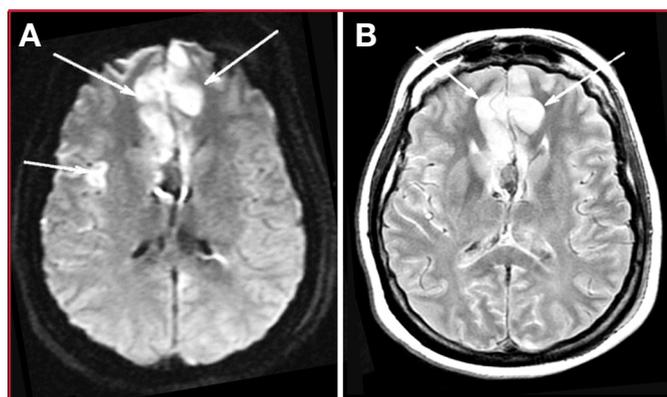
Diffusion-weighted (A) and fluid-attenuated inversion recovery (B) computed tomographic (CT) images demonstrating hemorrhage-related ischemic injury in both anterior and right middle cerebral artery territories (arrows) at admission in a 44-year-old woman with Hunt and Hess Grade V SAH from a left anterior cerebral artery aneurysm that was coiled on Day 3.
